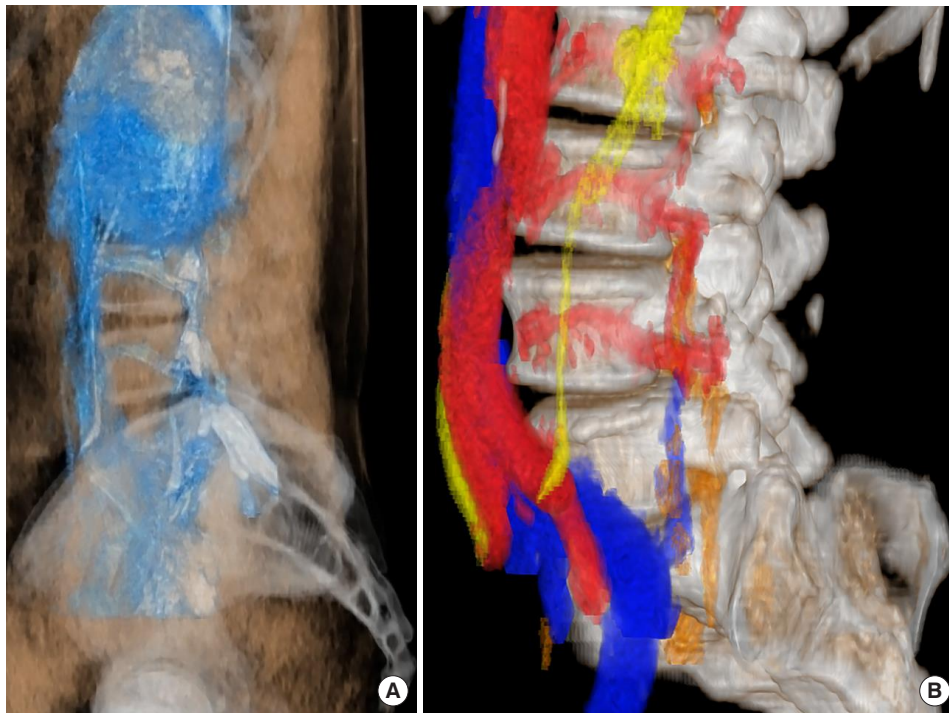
Three-dimensional computed tomography/magnetic resonance imaging fusion imaging. (A) Quick view. (B) Colored view. Red: artery, blue: vein, yellow: urinary tract, orange: nerve.
